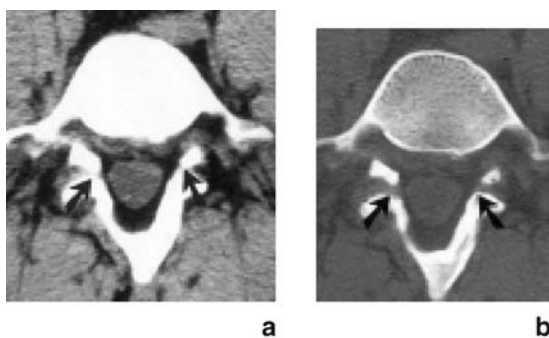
(a,b). CT diagnosis of isthmic spondylolysis (arrows) (a) standard reconstruction algorithm; (b) bone reconstruction algorithm
